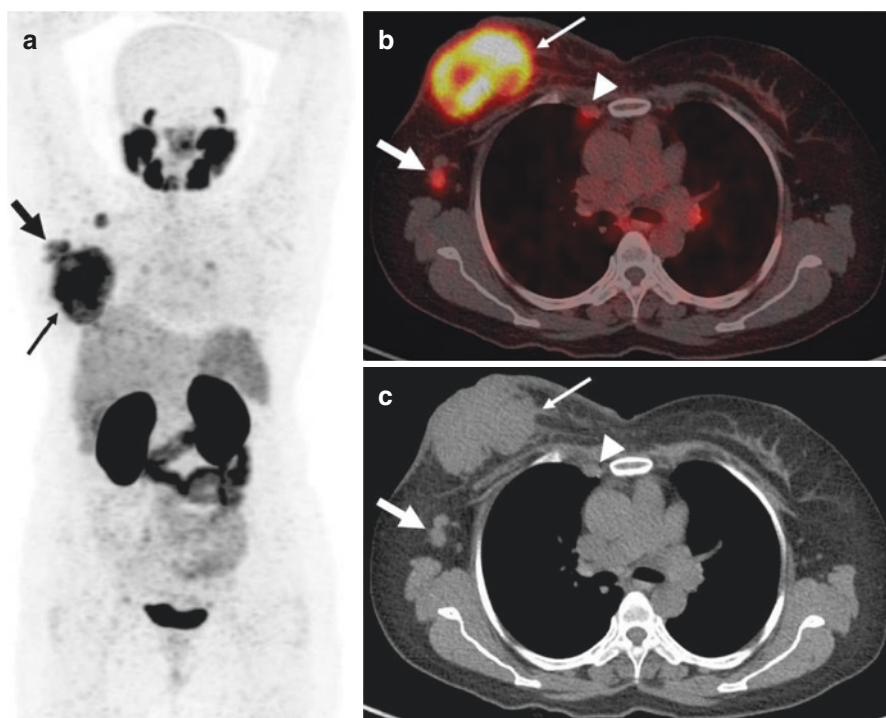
A 46 year-old-woman with newly diagnosed carcinoma right breast (IDC, grade II, triple negative). ^{68}Ga -PSMA PET/CT maximum intensity projection image (a), transaxial fused PET/CT (b) and CT image (c) show intensely tracer avid primary breast mass (thin arrow) and tracer avid sub-centimetric right axillary (thick arrow) and right internal mammary (arrow-head) lymph nodes, representing nodal metastases. Physiological radiotracer activity is also seen in the lacrimal and salivary glands, liver, kidneys, proximal small intestine and urinary bladder in the MIP image
